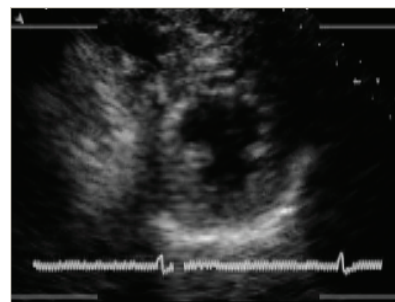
The short axis image left ventricular of cardiac cavity from echocardiography video.
